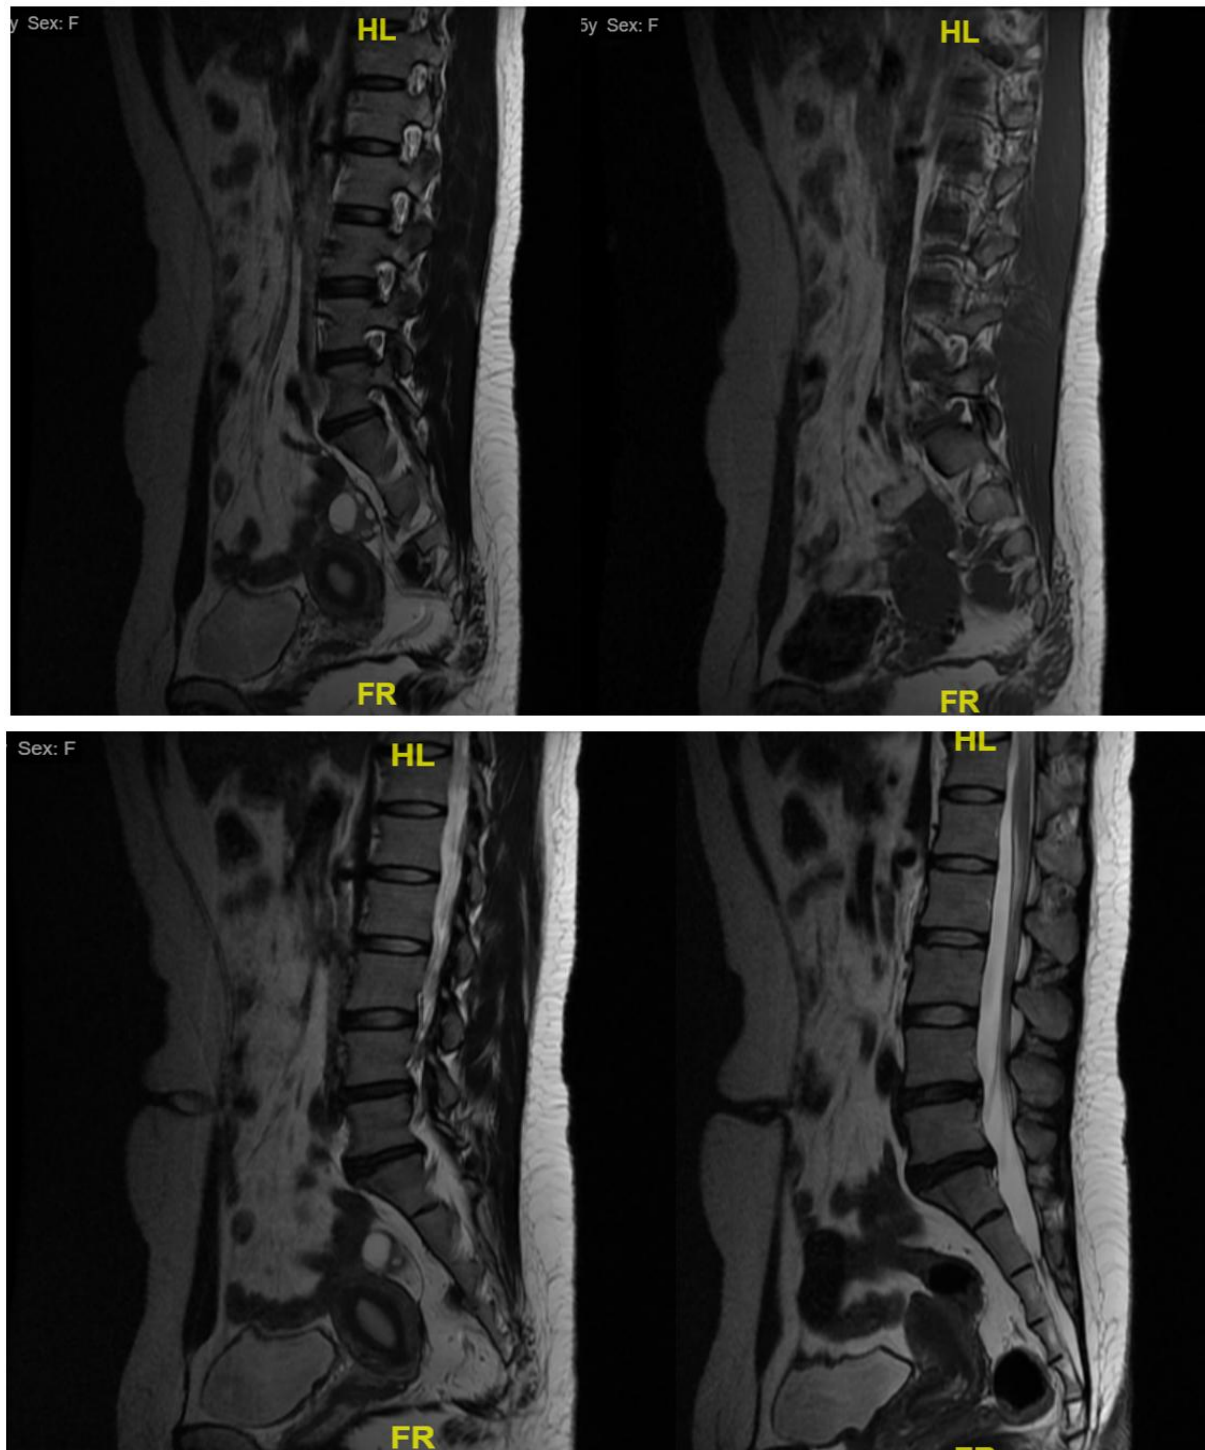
Non contrast lumbosacral MRI of the patient
